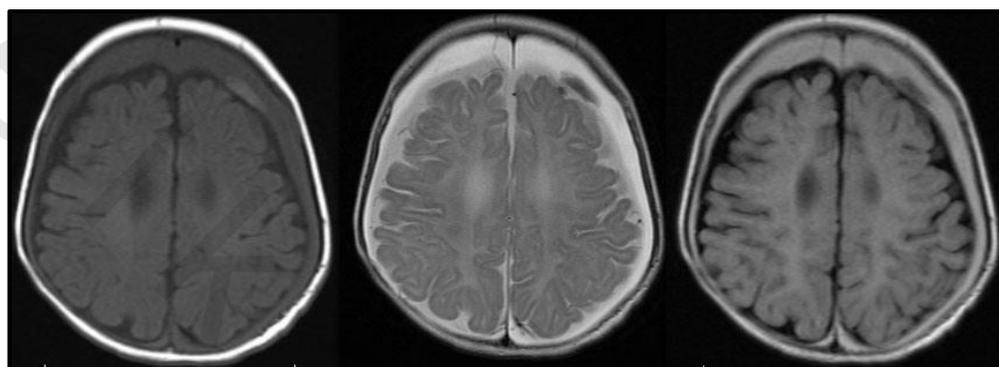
Radiological features of CSDH in MRI brain. Axial T1 (left), T2 (center) and FLAIR (right) weighted images from an MRI scan of the brain performed without intravenous contrast obtained at the same level as the previously performed CT scan of the brain better demonstrates the large, bilateral chronic subdural hematomas with the linear focus of acute subdural hematoma in the frontal aspect of the left chronic subdural hematoma. Note the appearance of the signal intensity of the CSF in the patient's normal subarachnoid space on the T1, T2 and FLAIR weighted images which are the same signal intensity as the CSF in the ventricular system.
